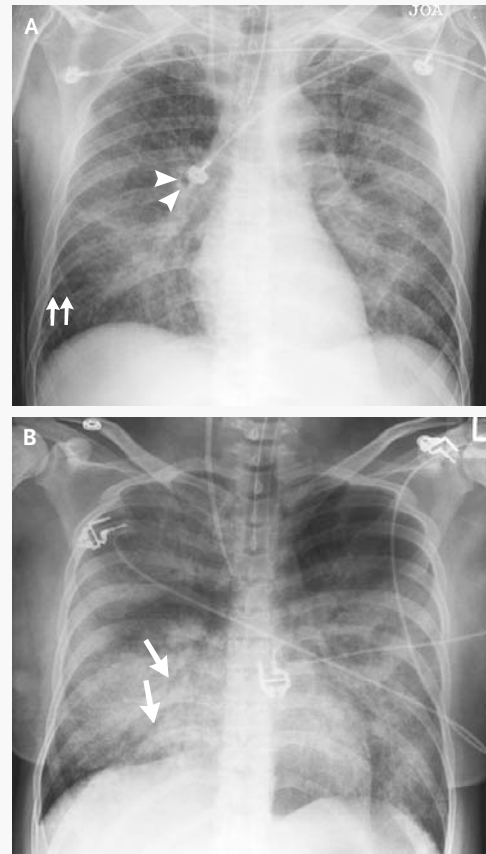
Representative Chest Radiographs from Patients with Cardiogenic and Noncardiogenic Pulmonary Edema.
